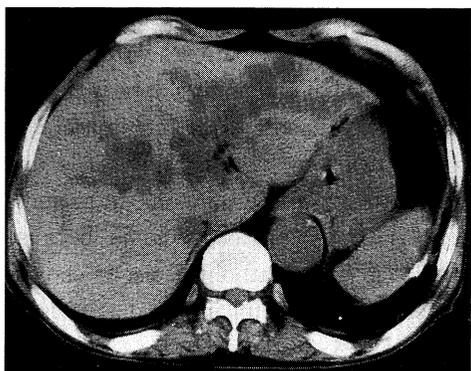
Unenhanced computed tomography of the liver demonstrated cystic dilatation of intrahepatic biliary tracts.
